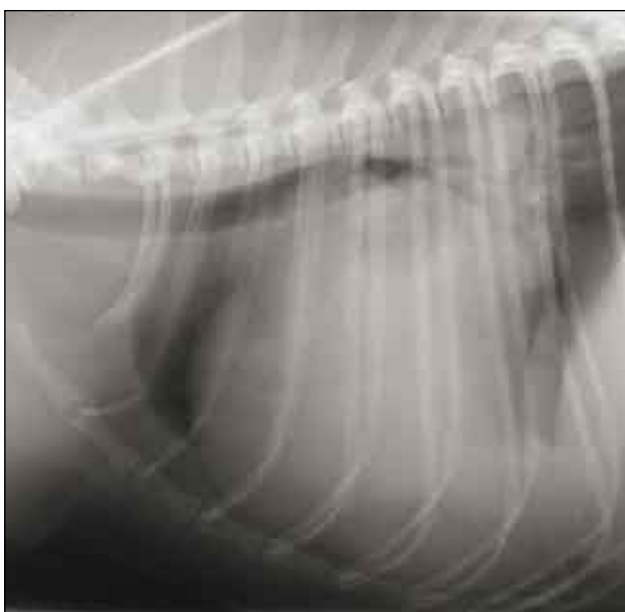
Right lateral recumbent thoracic radiograph of a three-year-old CKCS with marked cardiomegaly and enlarged left atrium secondary to mitral insufficiency due to underlying endocardiosis.
